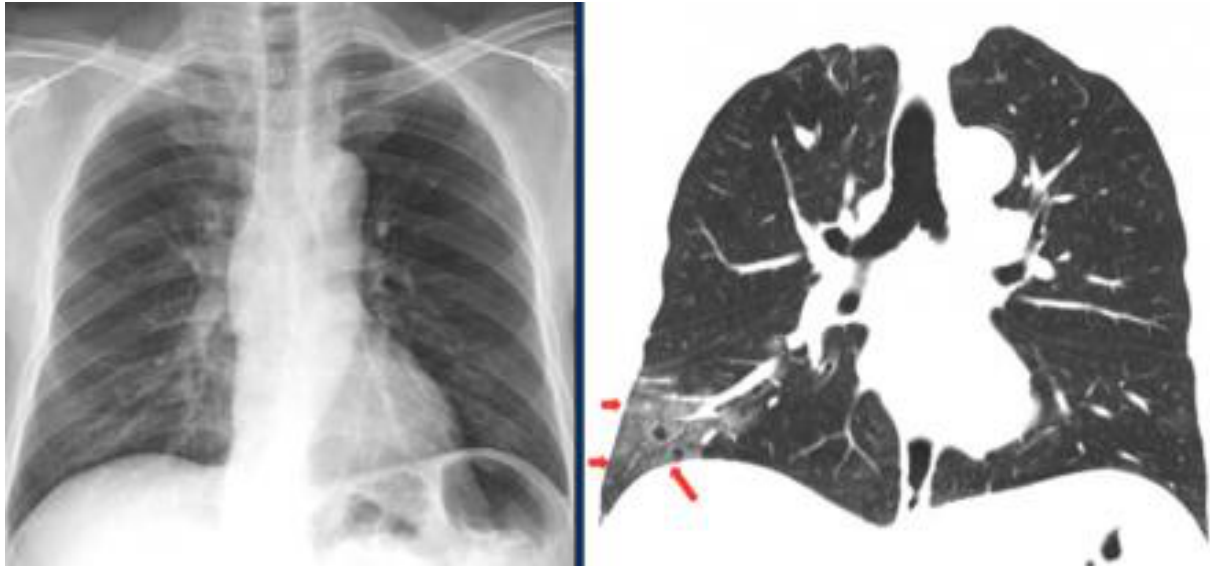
Comparison of CXR and coronal CT images of same patient demonstrates ground-glass opacification in the right lower lobe on CT which is not visible on the CXR performed within 1 hour.
